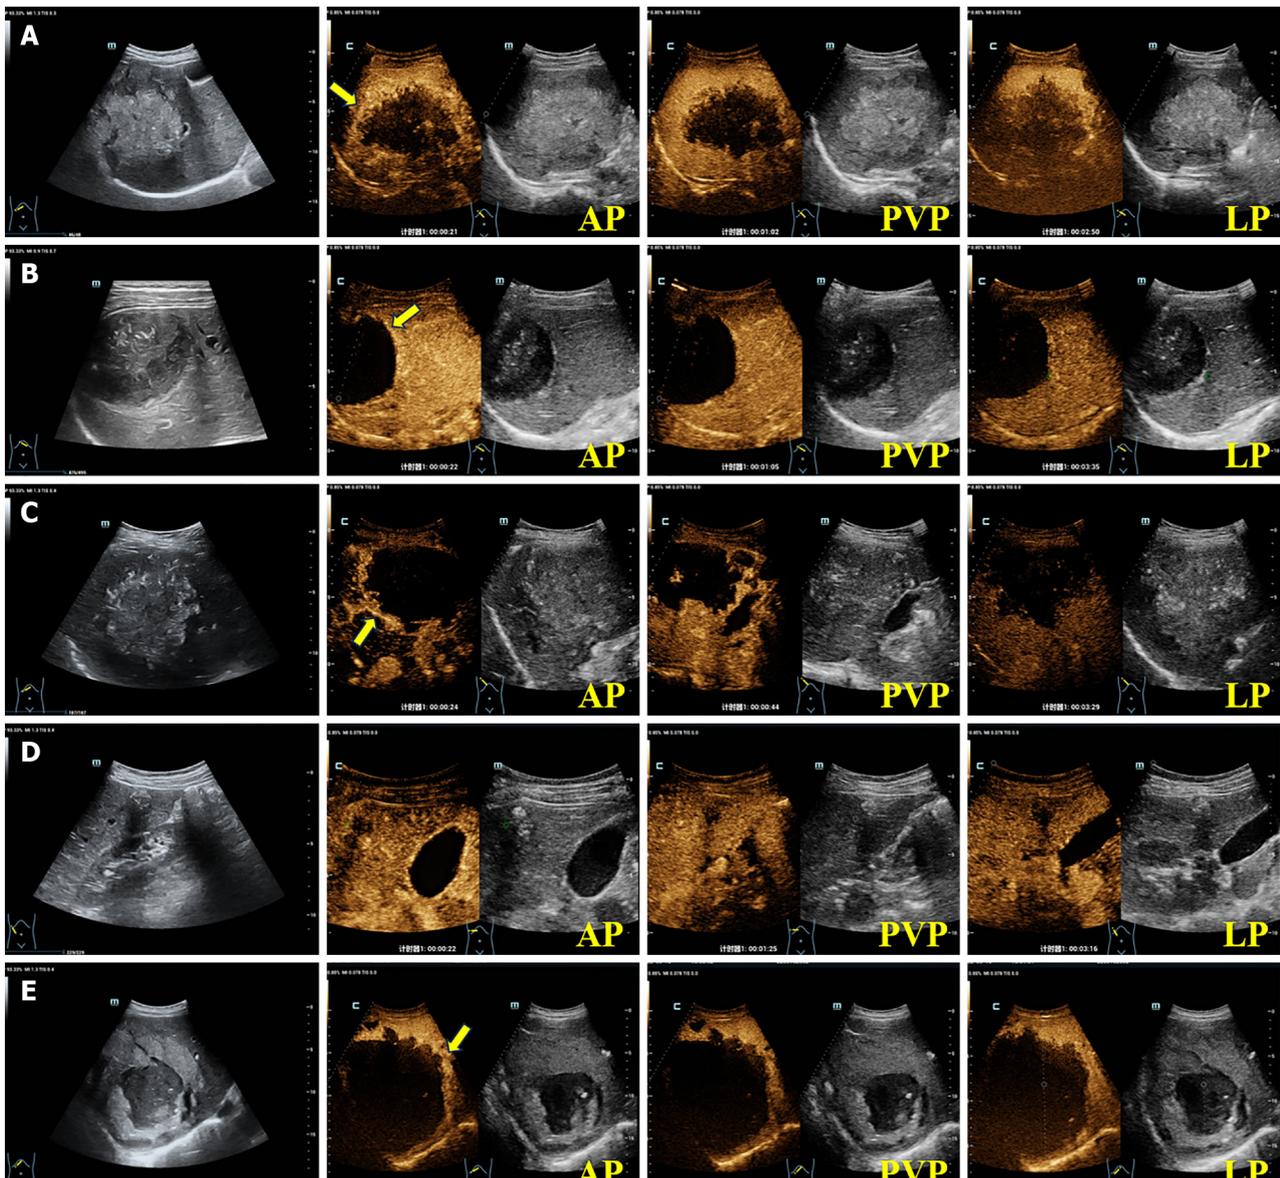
Contrast-enhanced ultrasound images of hepatic alveolar echinococcosis. A: A 55-year-old male patient presenting with a hemangioma-like hepatic alveolar echinococcosis (HAE) liver lesion, exhibiting peripheral “rim-like” enhancement in the arterial phase (AP) on contrast-enhanced ultrasound (CEUS) (the yellow arrow), with no internal enhancement; B: A 29-year-old female patient presenting with a metastasis-like HAE liver lesion, exhibiting peripheral “rim-like” enhancement in the AP on CEUS (the yellow arrow), with no internal enhancement; C: A 53-year-old female patient presenting with a hailstorm HAE liver lesion, exhibiting peripheral “rim-like” enhancement in the AP on CEUS (the yellow arrow), with no internal enhancement; D: A 50-year-old male patient presenting with an ossified HAE liver lesion, with no obvious enhancement in the AP, portal venous phase, or late phase; E: A 40-year-old female patient presenting with a pseudocystic HAE liver lesion, exhibiting peripheral “rim-like” enhancement in the AP on CEUS (the yellow arrow), but lacking internal enhancement.
